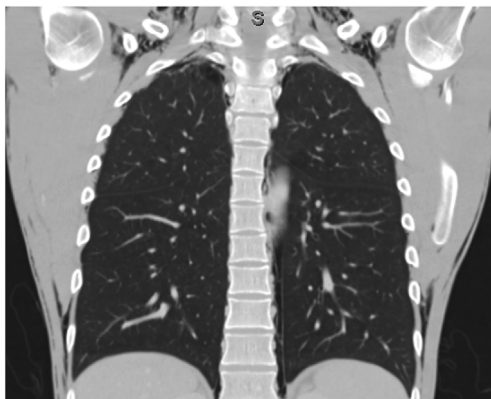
CT chest revealing small bilateral apical pneumothoraces and neck subcutaneous emphysema.
